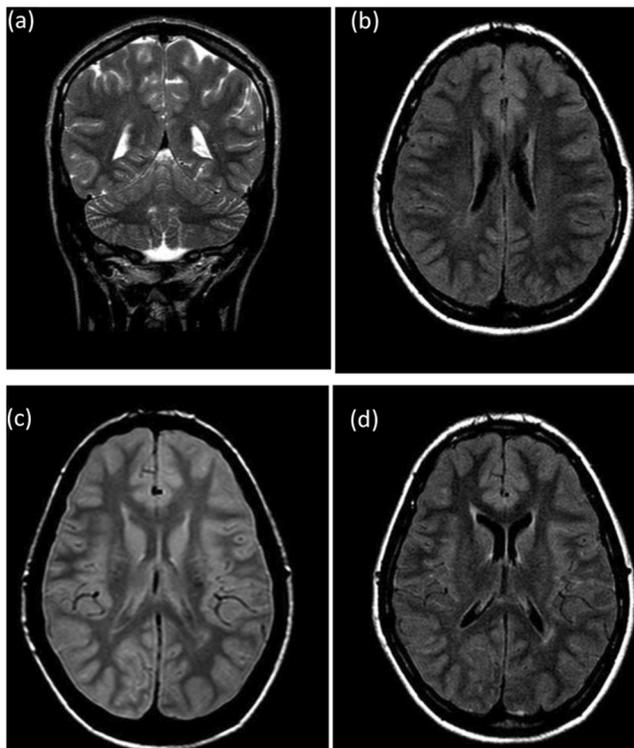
Brain MRI features. T2-weighted coronal image (a). FLAIR-weighted axial image by the level of the corona radiata (b). DP-weighted and FLAIR-weighted axial images through the superior plane of the basal ganglia (c and d). Posterior left periventricular white matter hypersignal can be observed as a non-specific finding (d). There is no atrophy of cerebellum or cerebrum (a, b). Basal ganglia are normal and the ventricles are not enlarged (a, c)
